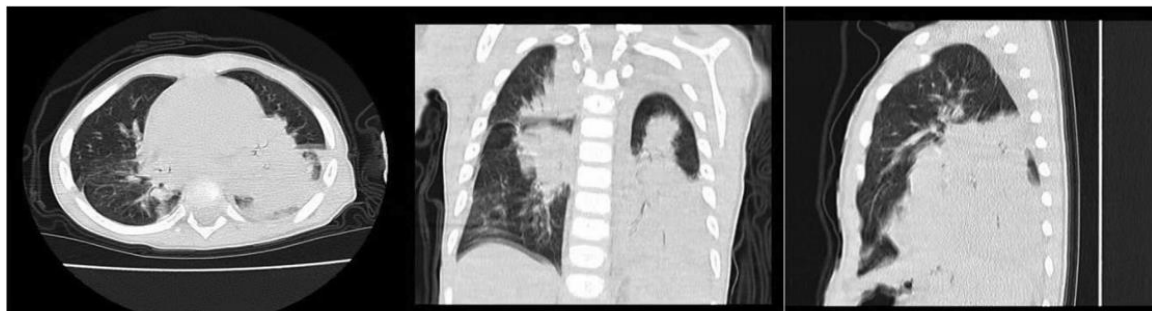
CT scan of the chest revealing areas of extensive consolidation mainly involved the left lower lobe and right upper lobe with a slight pleural in a 12-months-old child with severe adenovirus pneumonia.
